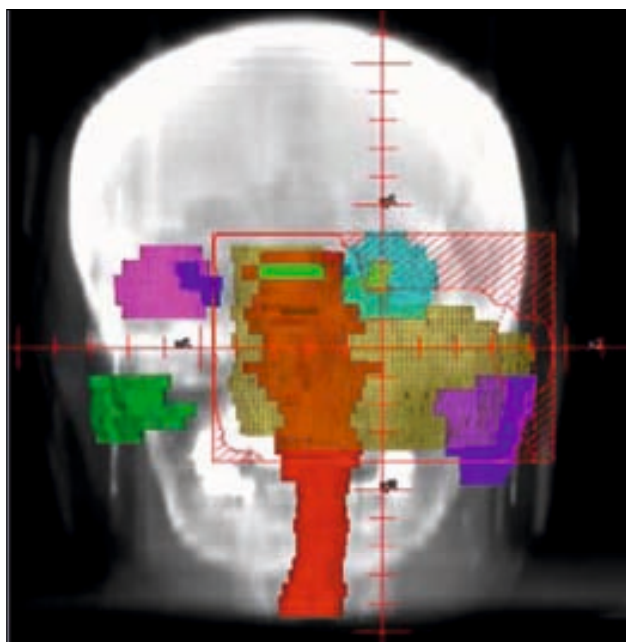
3-D conformal radiotherapy. This figure demonstrates the planning target volume (PTV) and a number of organs at risk (OARs) superimposed on a digitally reconstructed radiograph. The green box represents a so-called beam's eye view of a lateral field for the treatment of a maxillary antral tumour. The PTV overlaps the parotid glands, which means that these structures can not be shielded. OARs such as the spinal cord and the eyeballs have been shielded from radiation using multi-leaf collimators (MLCs) where they lie outside the PTV.
